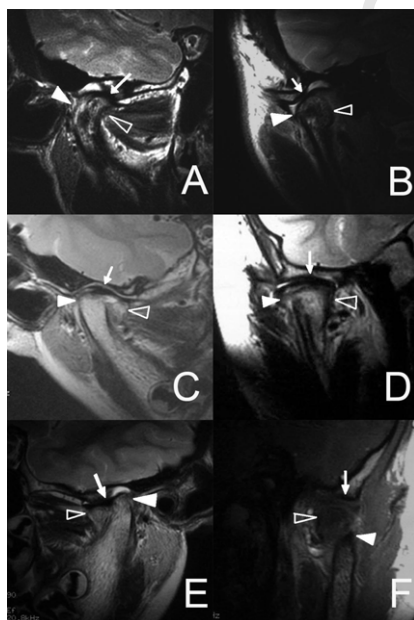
MRI images of type I and type II SFMCs. (A and B) In the case of the type I SFMC, both fractured fragment (hollow triangle) and lateral pole (solid triangle) were covered by the articular disc (arrow) on the sagittal (A) and coronal (B) sections. (C and D) In the case of the type II SFMC, both fractured fragment (hollow triangle) and lateral pole (solid triangle) were covered by the articular disc (arrow) on the sagittal (C) and coronal (D) sections. (E and F) In another case of type II SFMC, the fractured fragment (hollow triangle) was covered, and the lateral pole (solid triangle) was incompletely covered by the articular disc (arrow) on the sagittal (E) and coronal (F) sections.
